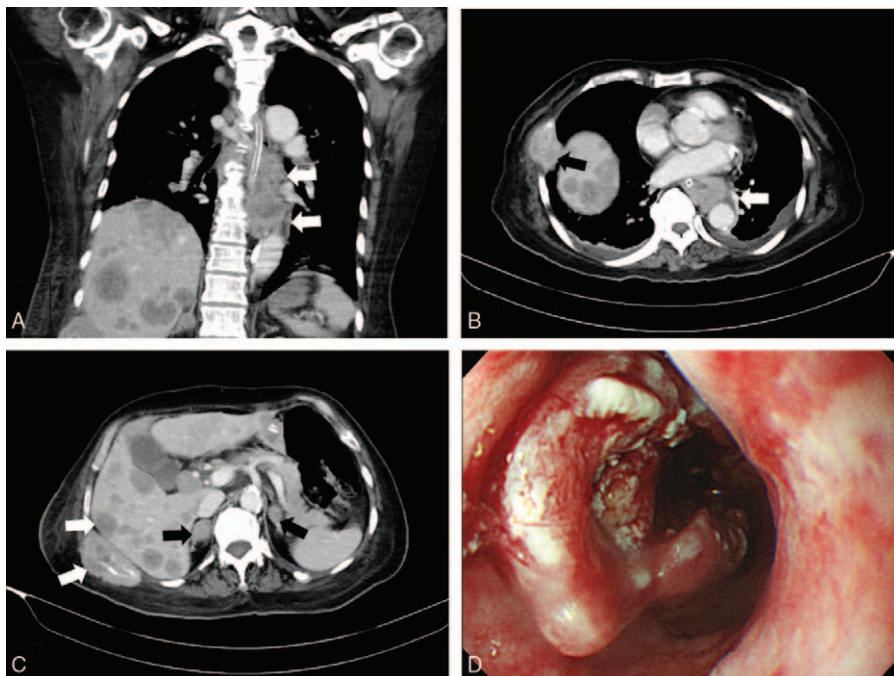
(A) Chest computed tomography in the coronal view showed that the length of the esophagus mass was about 7.9 cm (white arrows). (B) Chest computed tomography in the axial view revealed that the esophagus tumor had invaded the descending aorta (white arrow), and metastasis over the right 4th rib (black arrow). (C) Abdominal computed tomography revealed metastases over bilateral adrenal glands (black arrows), right 9th rib and multiple metastases of the liver (white arrows). (D) Panendoscopy showed a 7-cm ulcerated lesion in the lower third of the esophagus.
